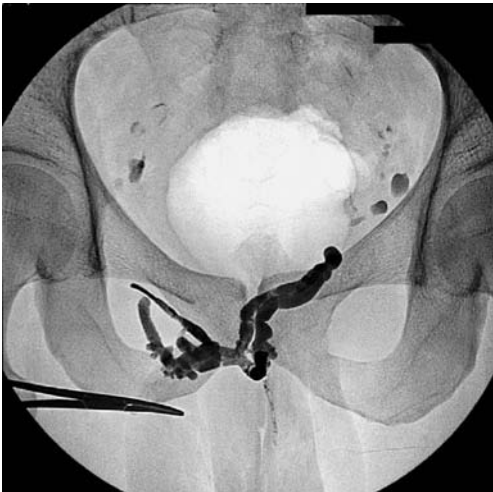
Digital roentgenogram showed occluded leaking veins after embolization.
